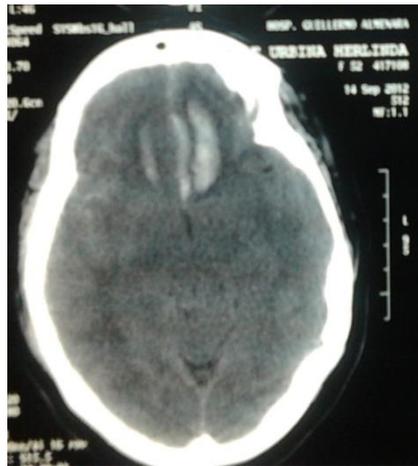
Brain CT at the beginning showing area of frontal intracerebral hematoma with minimal cerebral edema.
